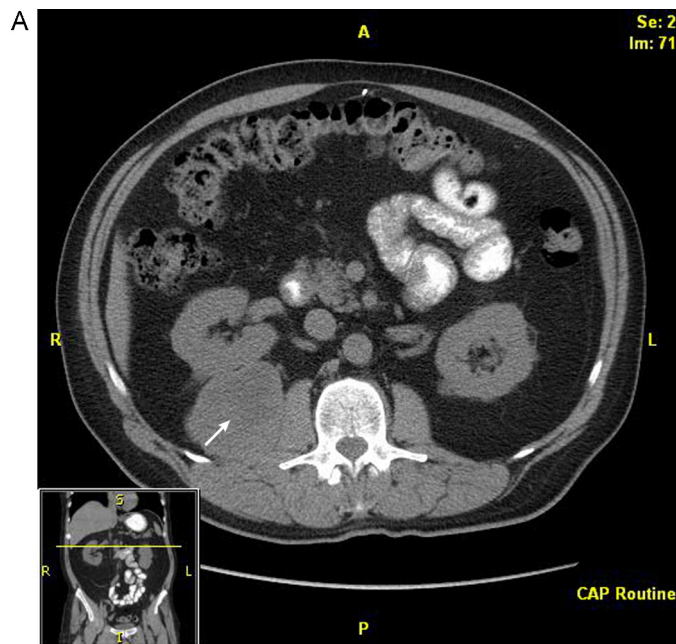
Computed tomographic scan showing metastases in the (A) right retrorenal retroperitoneum and (B) hepatic flexure attachments of the right colon. The arrow indicates the retrorenal metastasis.
